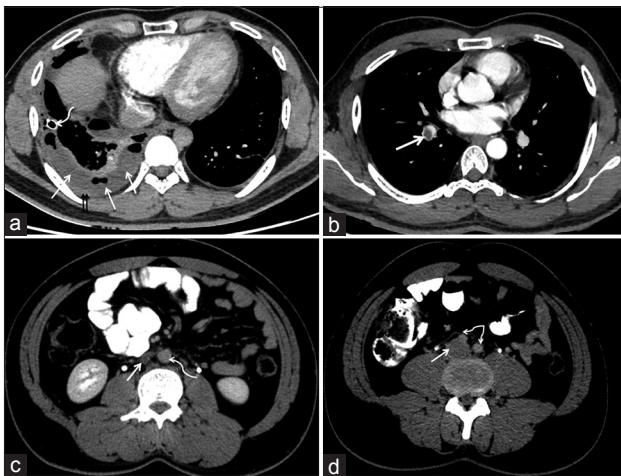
(a) Representative axial image from computed tomography pulmonary angiogram in mediastinal window showing loculated right pleural effusion with air pockets (arrows), mild pleural thickening and enhancement (double black arrows), intercostal drain tube (curved arrow). Although no definite pulmonary embolism could be detected, subsegmental pulmonary artery branches were not optimally assessed. (b) Representative axial image from computed tomography pulmonary angiogram in mediastinal window showing filling defects in the right lower lobe pulmonary artery (arrow) in keeping with acute pulmonary embolism. (c) Venous phase axial image at the level of the lower poles of the kidneys from contrast enhanced computed tomography abdomen showing narrowed caliber and nonenhancement of infrarenal inferior vena cava (straight arrow) suggesting a chronic thrombosis. Curved arrow – aorta. (d) Venous phase axial image at the level of the aortic bifurcation (bifid curved arrow) from contrast enhanced computed tomography abdomen showing dilated inferior vena cava with filling defect (straight arrow) suggesting an acute thrombus
